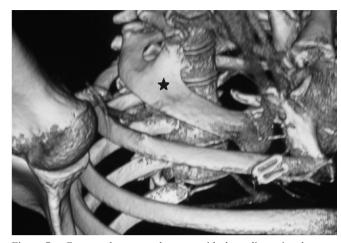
Computed tomography scan with three-dimensional reconstruction demonstrates a right anomalous first rib (marked with asterisk).
